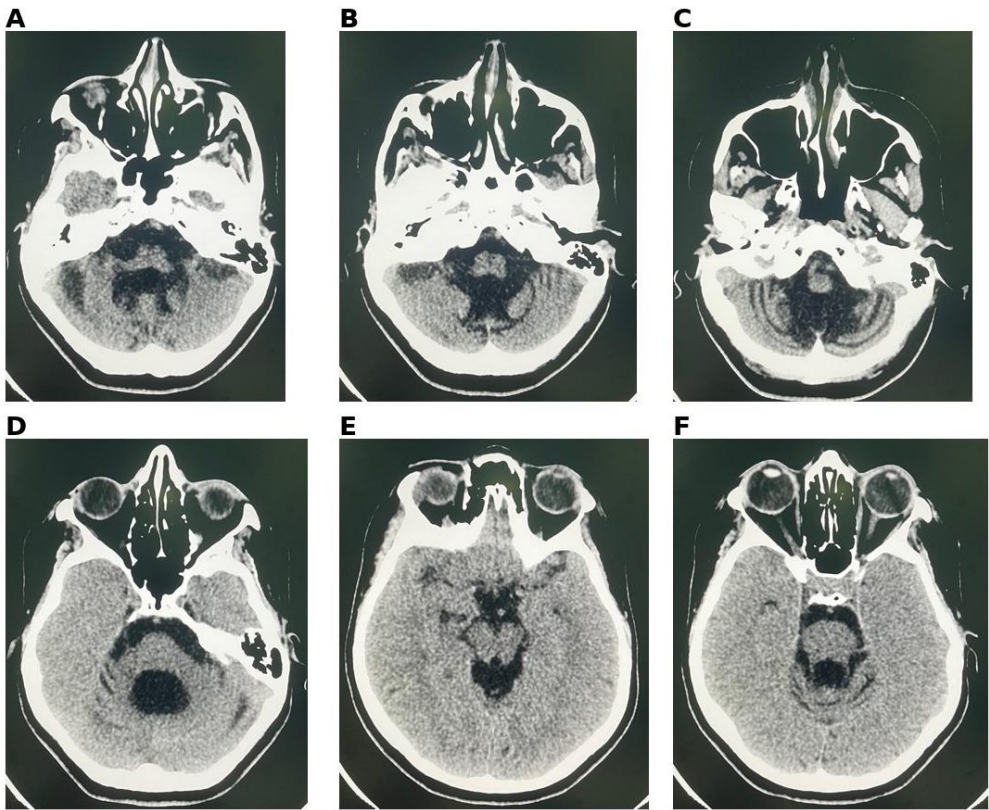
Computed Tomography imaging of the brain demonstrating cerebellar vermis atrophy and generalized cerebellar volume loss, with significant dilatation of the fourth ventricle and prepontine cistern (A-F).
